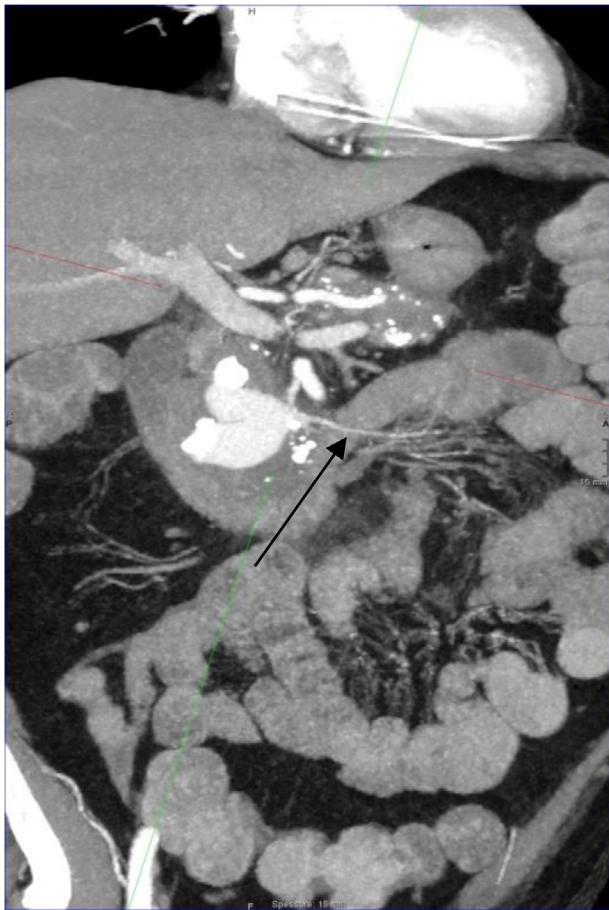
Coronal contrast-enhanced CT. Digiunl artery feeding the pseudoaneurysm (arrow).
